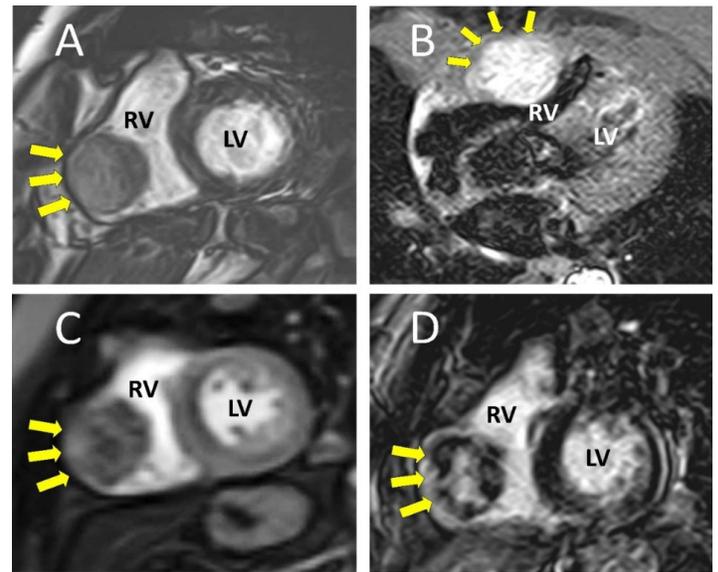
Contrast-based Cardiac Magnetic Resonance. Panel A: CMR-Cine imaging in the short axis view showing a round-shaped mass at the level of the basal lateral wall of the right ventricle with well-demarcated borders (arrows). Panel B: STIR-T2-weighted imaging in the 4-chamber long axis view, showing hyperintense signal of the entire cardiac mass (arrows) indicating high water content (vascularized tissue). Panel C: CMR-Perfusion imaging in the short axis showing heterogeneous perfusion of the mass (vascular structure). Panel D: CMR-Late Gadolinium enhancement imaging in the short axis view showing heterogeneous contrast enhancement typical of a vascular mass. LV: left ventricle; RV: right ventricle.
